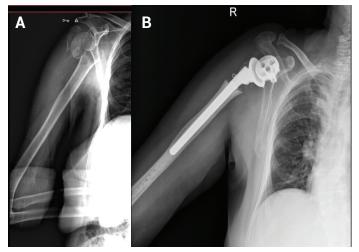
A. Four-part proximal humerus fracture, preoperative x-ray B. Post operative x-ray of the patient. The treatment was reverse shoulder arthroplasty
